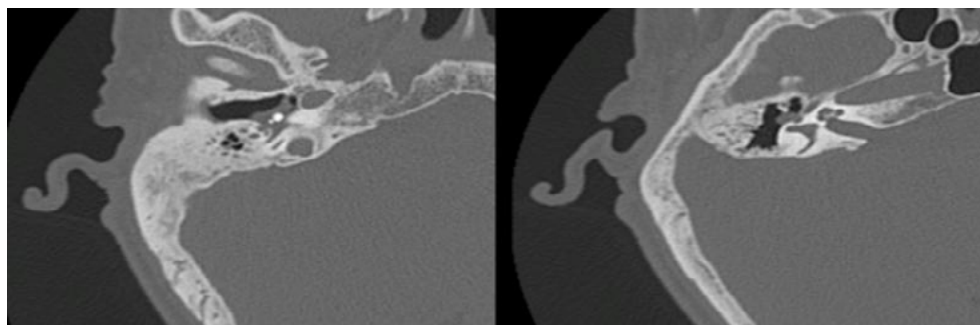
Computed tomograms of the temporal bones, axial projection. Condition after cochlear implantation on the right. CT signs of right-sided otitis media with cholesteatoma and signs of osteolysis of the auditory ossicles
